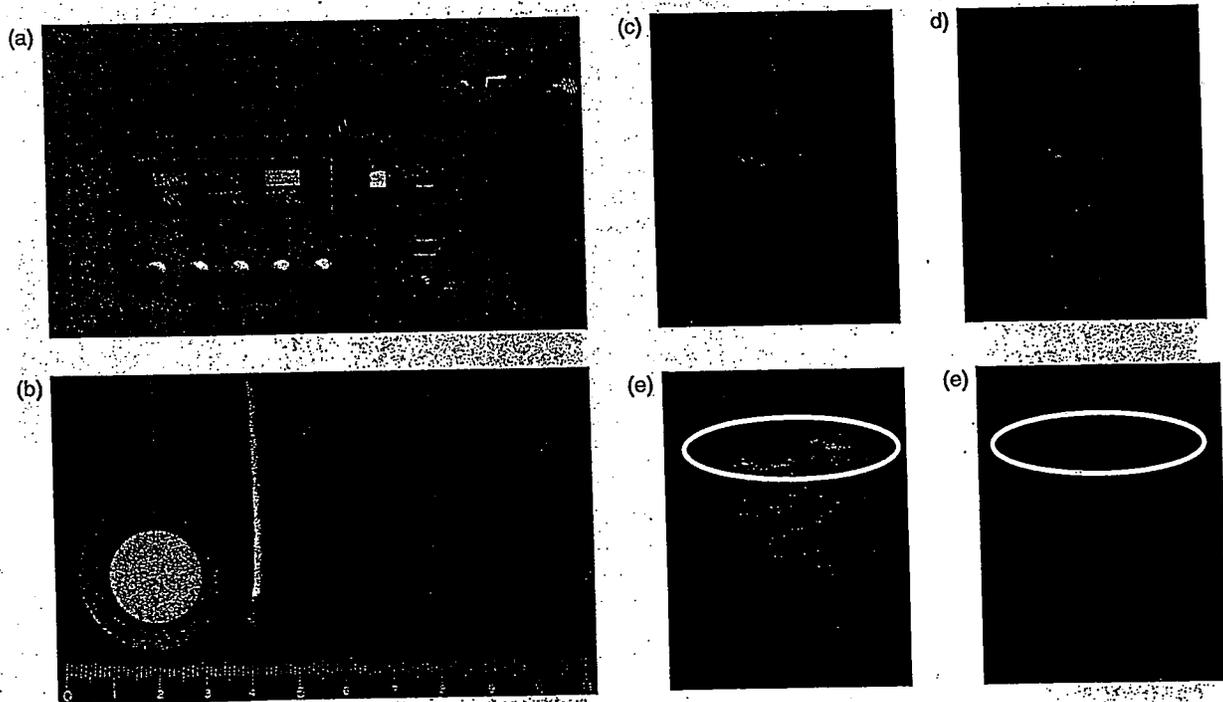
Cavitation of Bubble liposomes exposed with ultrasound. (a) Ultrasound generator. (b) Its probes. (c, d) Bubble liposomes were observed with naked image and (e, f) ultrasonography. The probe (circle) of ultrasound exposure was steeped in the suspension of Bubble liposomes. Then, they were exposed with ultrasound (2.5 W/cm²) for 10 s. (c, e) Images were observed before (d, f) and after ultrasound exposure.
